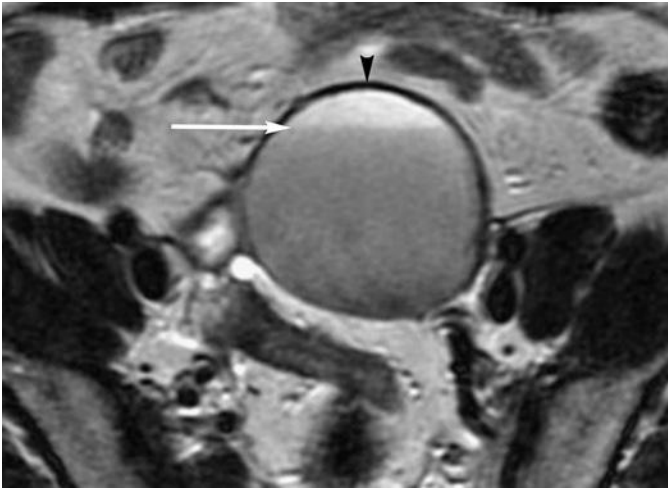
Ovarian endometrioma. Axial T2-weighted image shows a fluid-fluid level (*arrow*) with decreased signal intensity of the dependent portion, darker than the nondependent fluid seen anteriorly. This dependent area demonstrated higher signal intensity on the corresponding T1-weighted image (not shown). The drop in signal intensity between T1- and T2-weighted sequences is termed shading and is believed to be due to the presence of methemoglobin or other iron products. This layering effect has been referred to as the parfait sign and indicates the presence of blood products of varying ages within the endometrioma. Another common finding on magnetic resonance imaging of endometriomas is a very dark peripheral rim (*arrowhead*) due to hemosiderin deposition, also the result of blood degradation.
